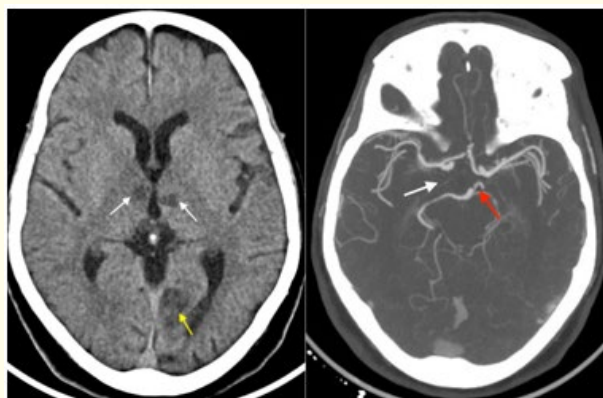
Patient 1: Brain CT contrast enhanced: (a) and CTA (b) in an axial plane:
